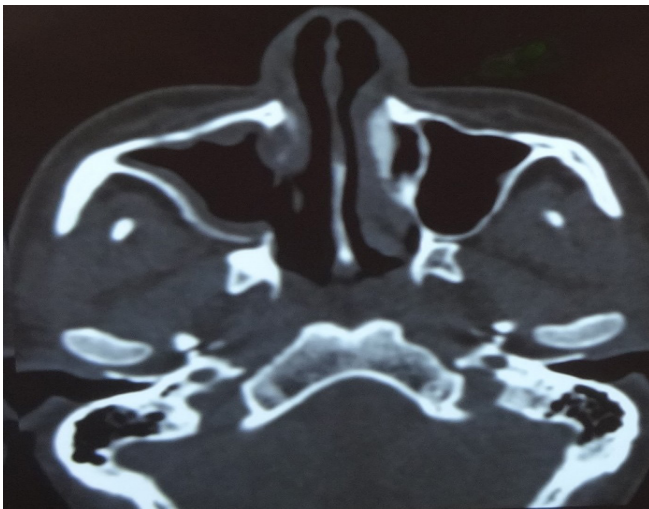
Post operative CT nose PNS
